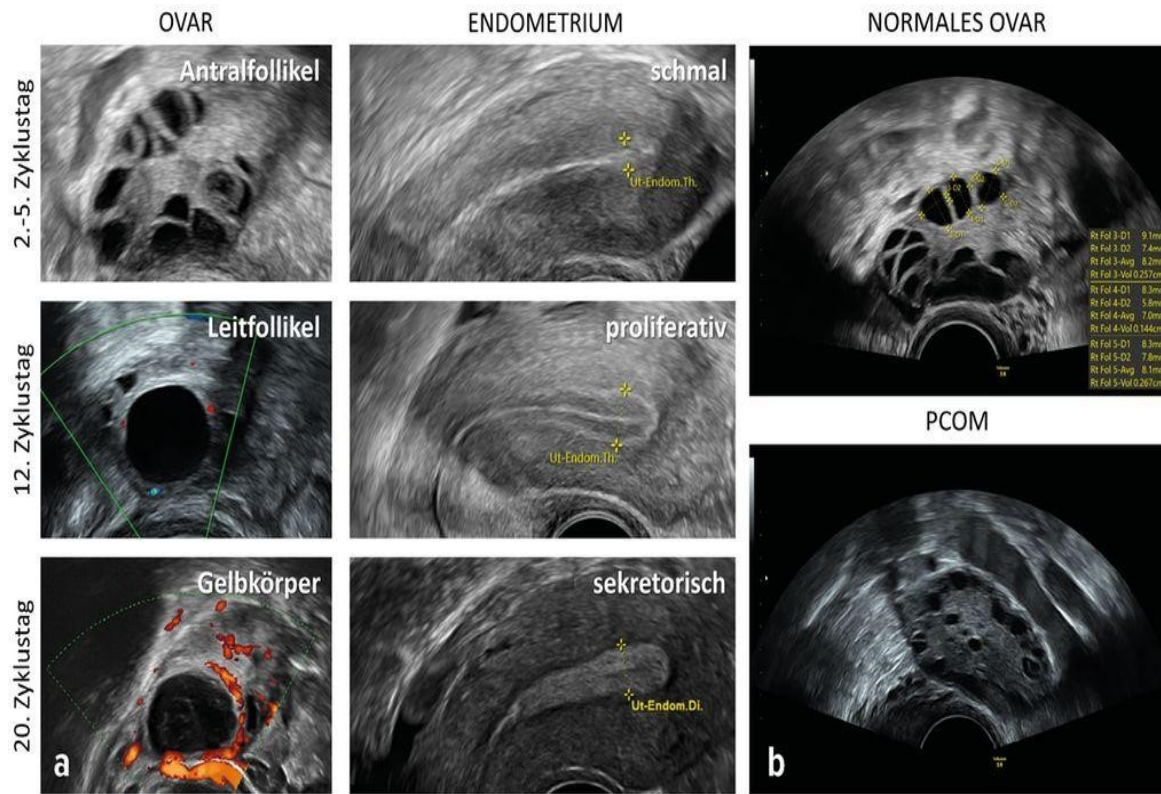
Ultrasound appearance of normal ovarian physiology and polycystic ovarian morphology (PCOM). Left panel shows follicular and endometrial changes during different phases of the menstrual cycle, including antral follicle, dominant follicle, and corpus luteum formation. Right panel compares a normal ovary with polycystic ovarian morphology characterized by multiple peripheral follicles and increased stromal tissue.
